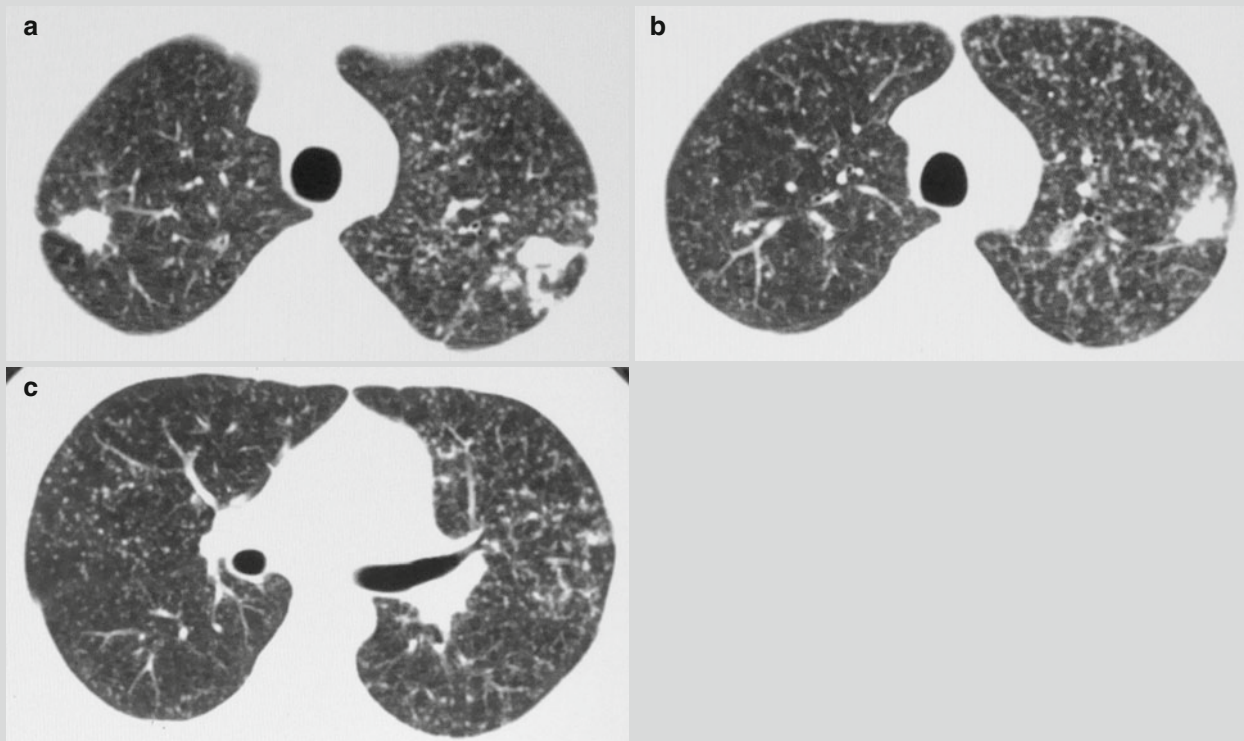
Subacute hematogenous pulmonary TB. (a–c) CT scanning demonstrates diffuse miliary nodules at both lungs, with different size and density. Some miliary nodules fuse together at the upper lobe of both lungs
